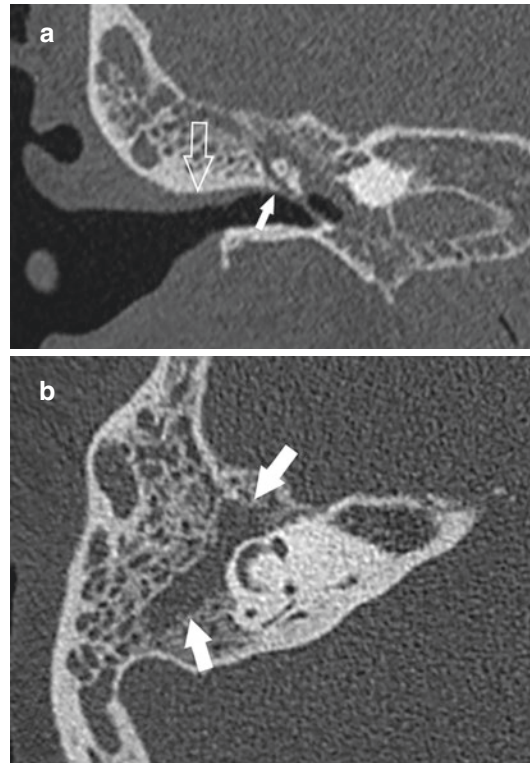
Tuberculous otomastoiditis. (a) Coronal CT image shows mucosal thickening along the roof of external auditory canal (open arrow). The scutum is intact (small solid arrow). (b) Axial CT image shows total opacification of the middle ear cavity, aditus ad antrum, mastoid antrum, and mastoid air cells (large solid arrows). Note that the opacified mastoid air cells are well developed and show no sclerosis
